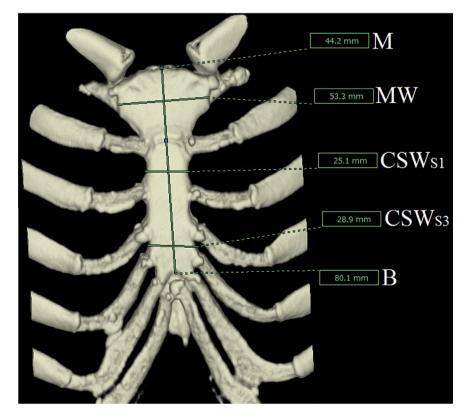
A reconstructed three dimensional computed tomographic image showing five measurements of the sternum (M, manubrium length; B, sternal body length; MW, manubrium width; CSW_{S1}, corpus sternal width at first sternebra; and CSW_{S3}, corpus sternal width at third sternebra) in the coronal plane viewed from the anterior side of the body.
